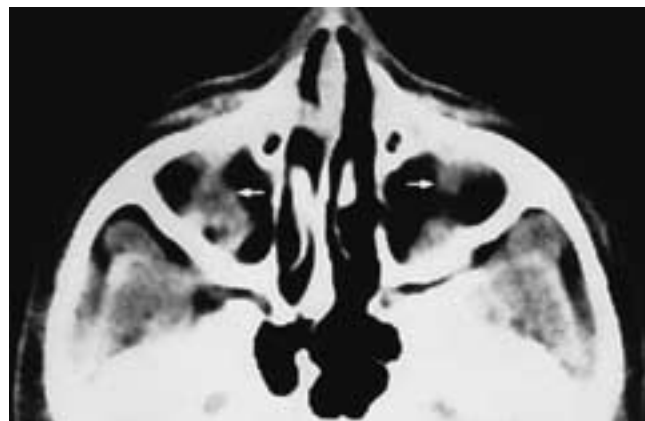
Axial CT scan through the upper maxillary sinuses shows the inferior rectus muscles (*arrows*) and orbital fat in the upper antra. The orbital floors have been surgically removed. This patient had thyroid ophthalmopathy and bilateral orbital floor decompressions.
